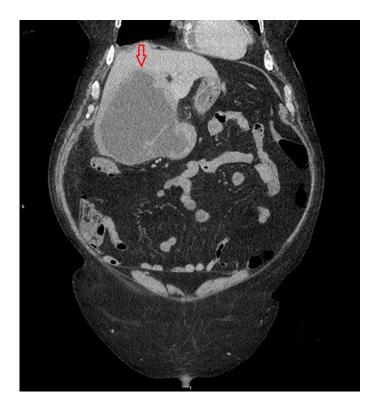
Coronal CT image showing a markedly distended and irregularly shaped intrahepatic gallbladder (red arrow) with surrounding edema.
